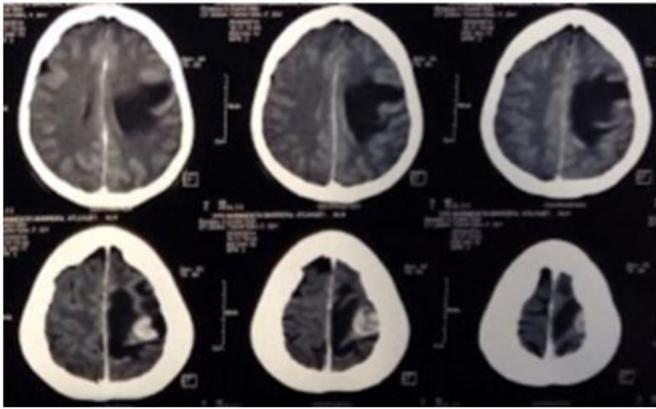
Contrast-enhanced CT is showing single lesion in the left parietal cortex with abundant perilesional oedema.
